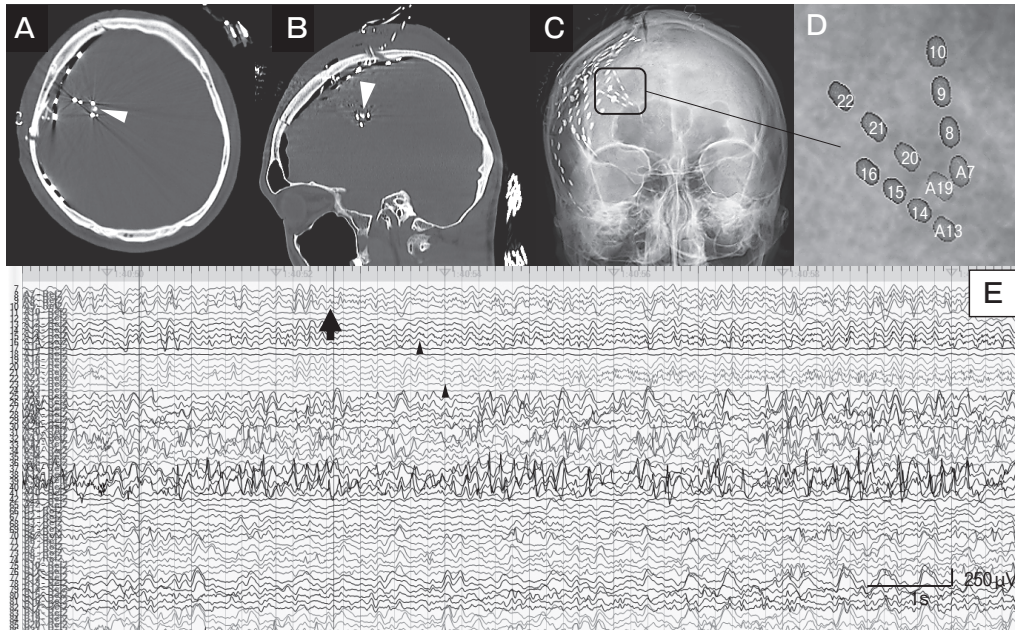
Intracranial electroencephalogram study. (A,B) CT scans obtained after the implantation of intracranial electrodes. Arrowheads indicate a calcification, and the surrounding high densities indicate the depth electrodes. (C) Subdural and depth electrodes were implanted in the right frontal area. (D) Higher magnification of the black box in (C) shows a 3D image of the depth electrodes. (E) Ictal electrocorticography indicates that the ictal 30 Hz activities (arrow) began at the depth electrode placed near but two contacts away from a calcification (electrode number 9 in [D]), and then the ictal discharges (arrowheads) propagated to the surrounding electrodes (electrode numbers 8, 15, 16, 21, and 22).
